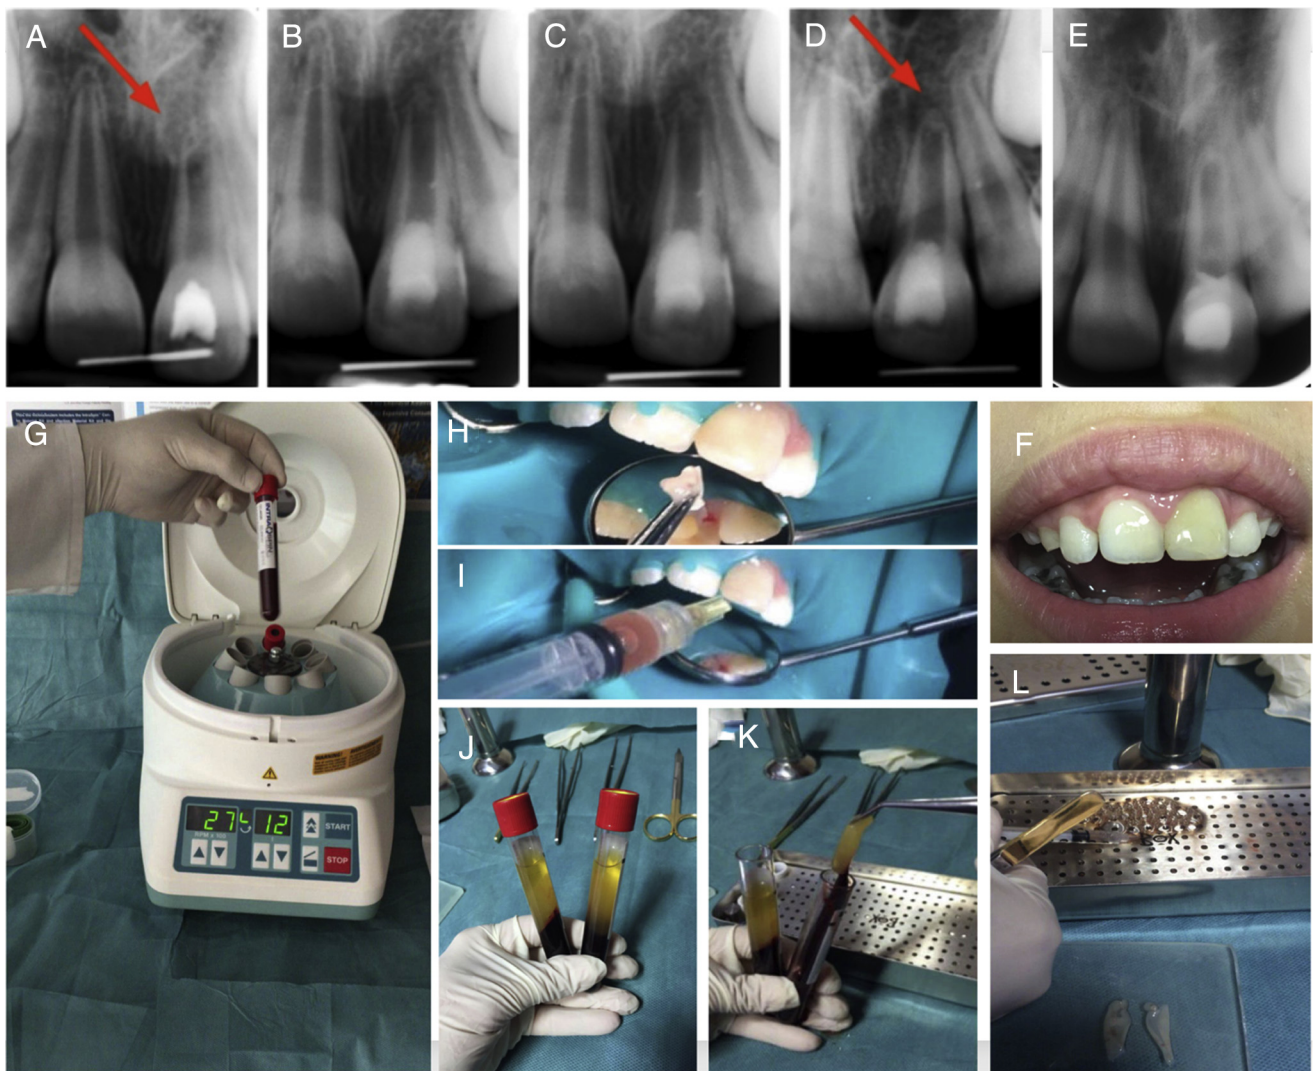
(A) A 9-year-old girl with a history of avulsion of the left maxillary central incisor with a periapical abscess and a necrotic tooth with an open apex (red arrow). Radiographs taken at the (B) 1-month, (C) 3-month, and (D) 6-month follow-ups revealed signs of appreciable complete apical closure after 6 months (red arrow). (E) The 18-month follow-up indicated further apical closure. (F) Minimal discoloration after 18 months was noticeable. (G) The sterile tubes were centrifuged at 2700 rpm for 12 minutes. (H) The small pieces of PRF clot were placed in the root canal. (I) The root canal was irrigated with the liquid in which the PRF clot was floated. (J and K) Three parts were formed in tubes, and the intermediate layer of PRF clot was collected. (L) The PRF clot was rolled over on itself on the glass slab. The small piece of wire placed in the radiographs are intended for measurement software calibrations.
